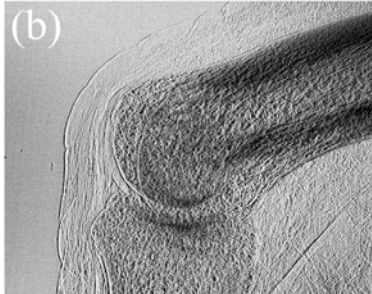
X-ray images of normal PIP joint with an intensifying screen.
